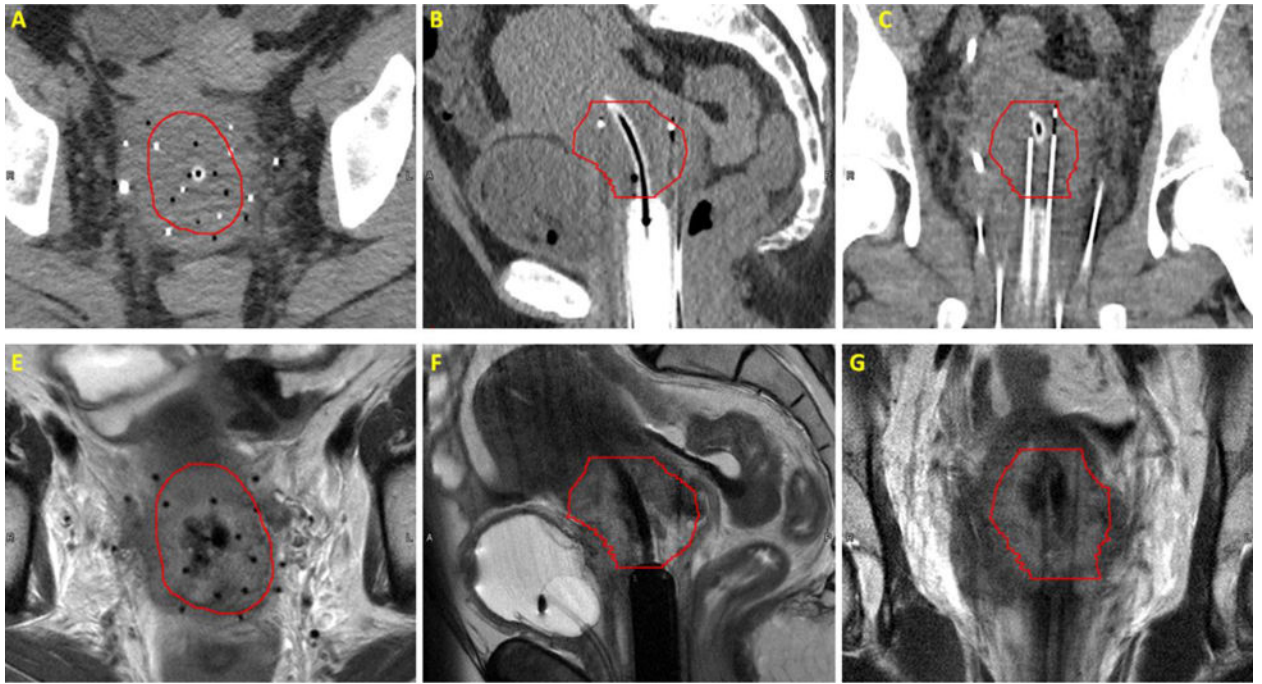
Comparison of CT and T2-weighted images of a patient with plastic needles and a plastic cylinder and tandem in place; Transverse view of CT (top row) and T2-weighted (bottom row) of a patient's pelvis with axial view showed in left panel and sagittal and coronal views showed in middle and right panels, respectively. High-risk CTV volume shown in red.
